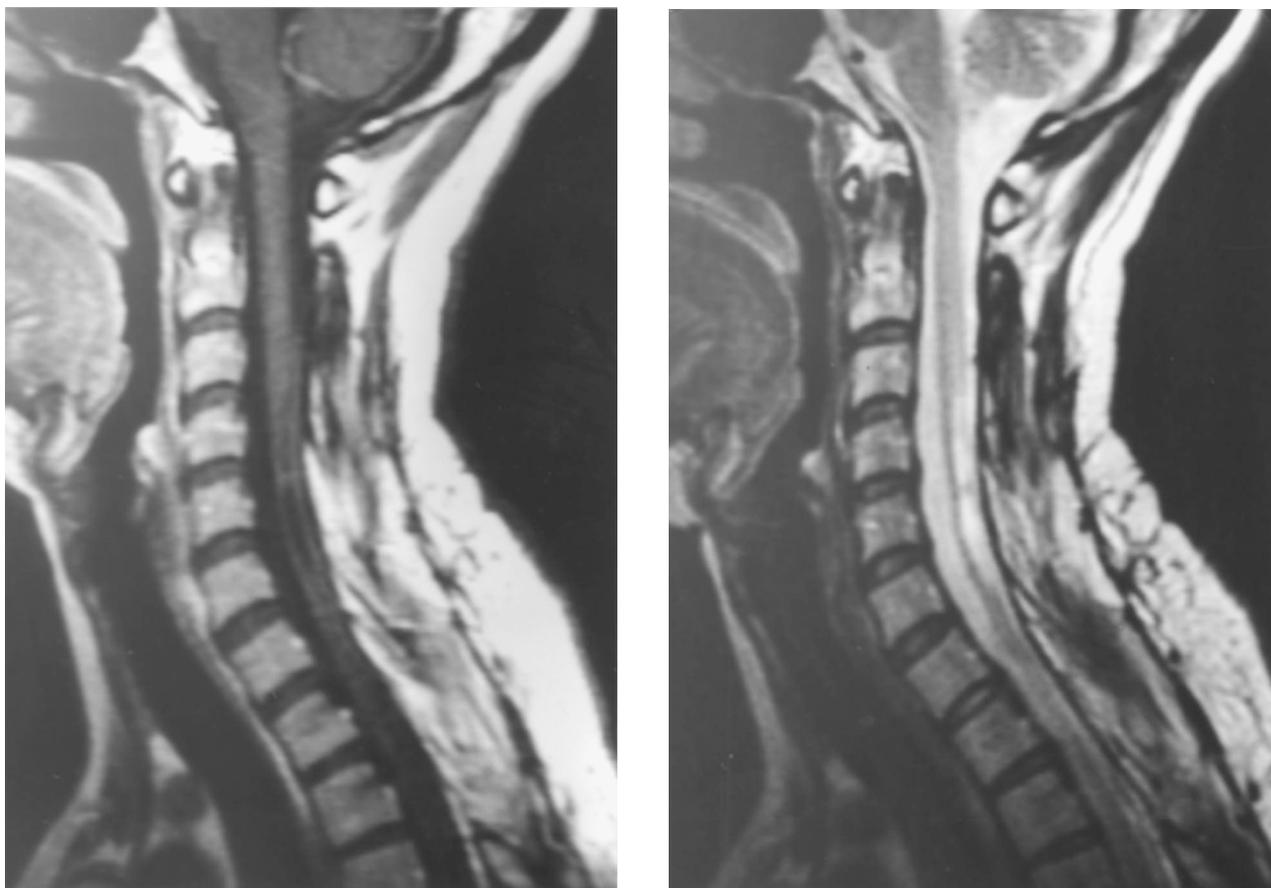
Post operative MR image (left: T1W Gd enhanced/right: T2W) demonstrated no recurrence from the tumors
